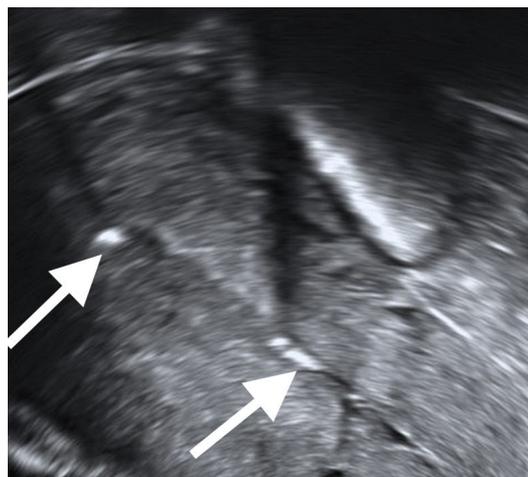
2D endovaginal examination- longitudinal plane ultrasound- multiple bright echo within the endometrium with some posterior acoustic shadowing in the uterine cavity.
